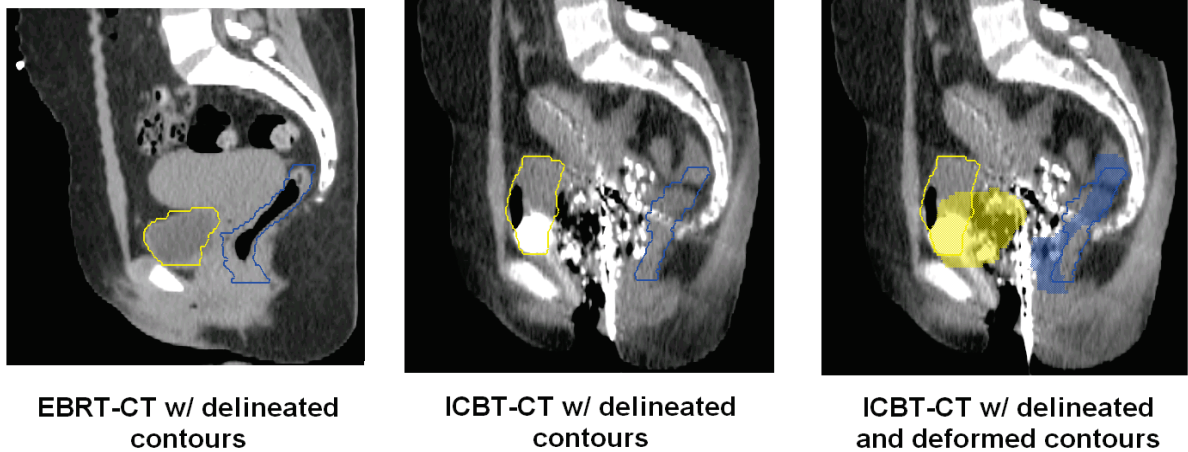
Example showing the differences between EBRT-CT and ICBT-CT with the bladder (yellow) and rectum (blue) delineated by a radiation oncologist. The image on the right shows deformed contours (colorwash) mapped onto the ICBT-CT image. One can see that neither bladder nor rectum agreed well with radiation oncologist delineated contours.
